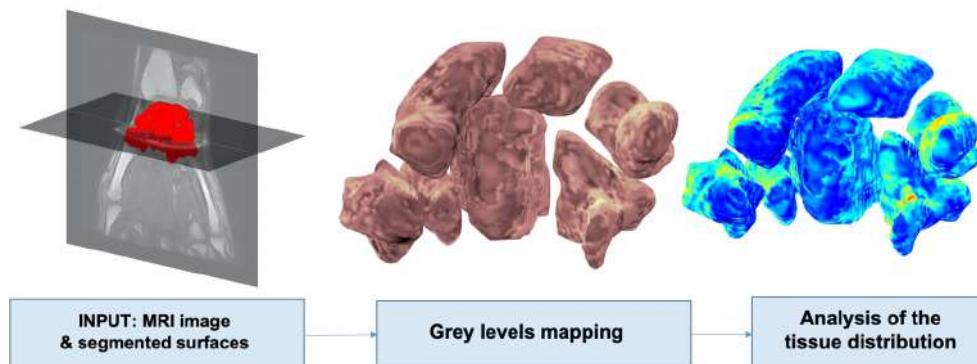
Overview of the novel approach: MR images and segmentation of the hand-wrist district, textured surfaces by mapping grey-level onto the bone surfaces, identification of tissue distribution inside the surface (darker blue correspond to darker tissues in the original volume; while brighter toward yellow and red correspond to brighter tissues in the original volume).
